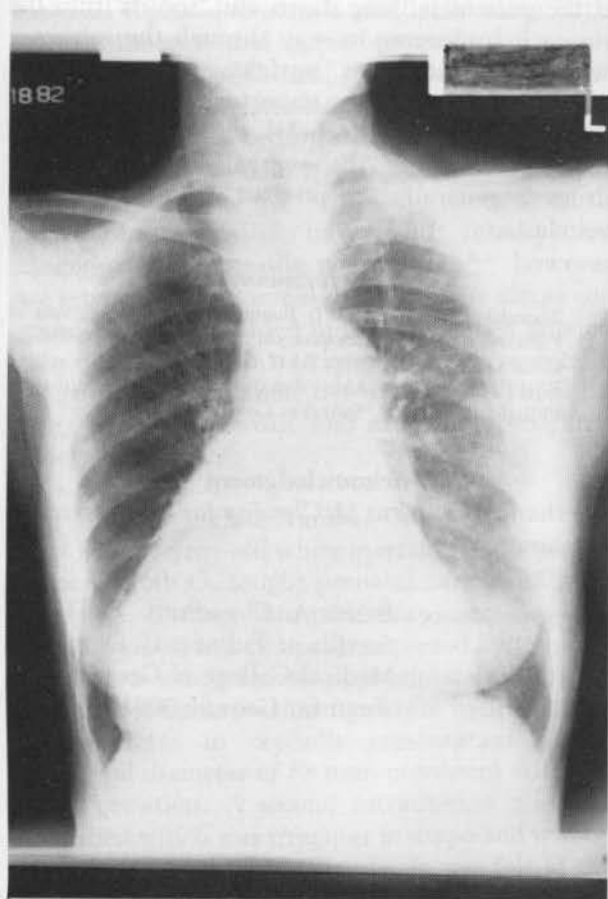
PA Chest roentgenogram
